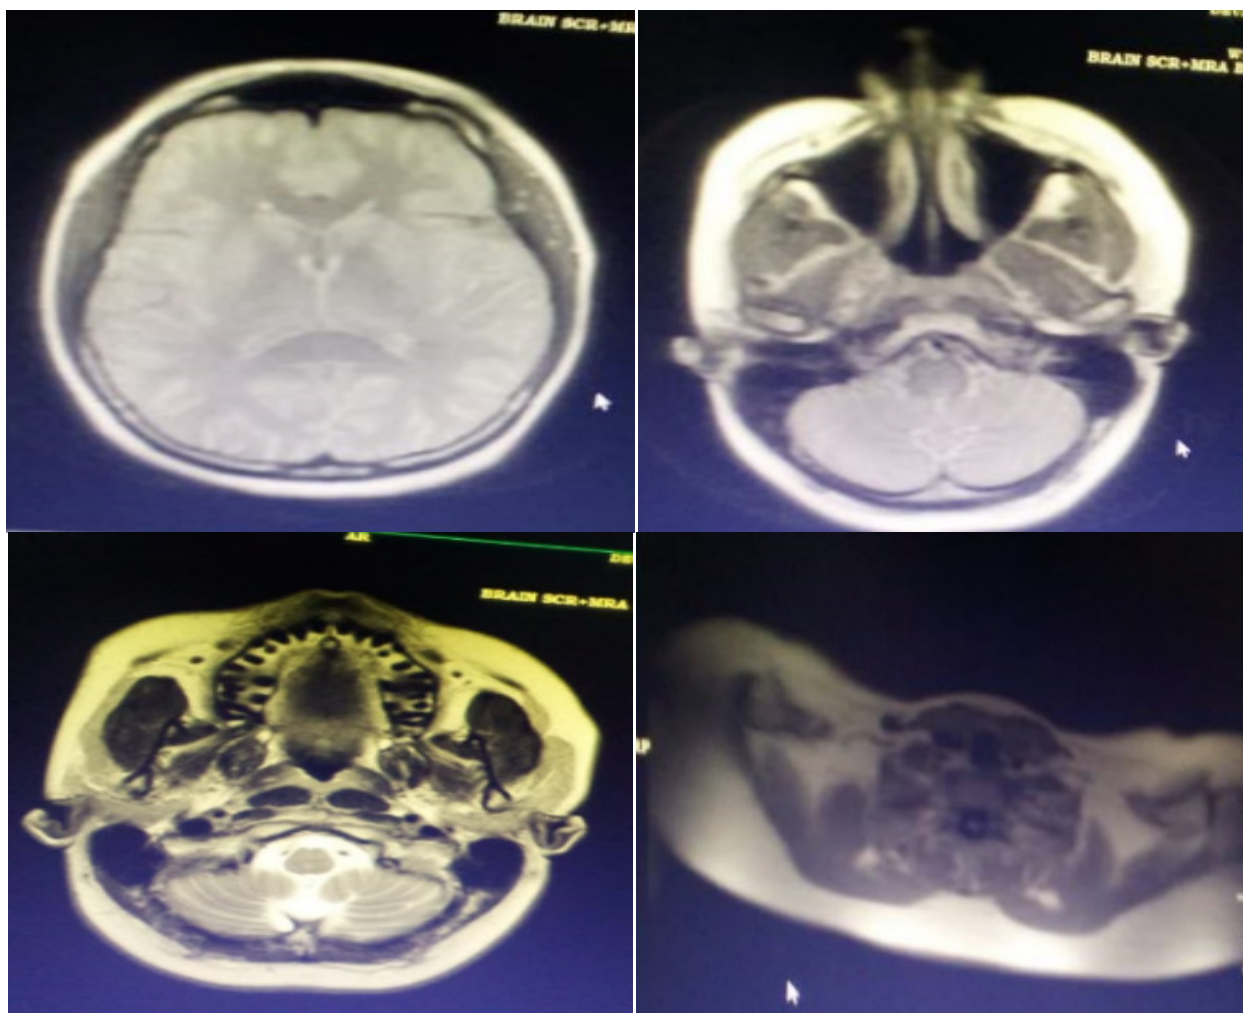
Magnetic resonance imaging of brain showed no acute infarct.
